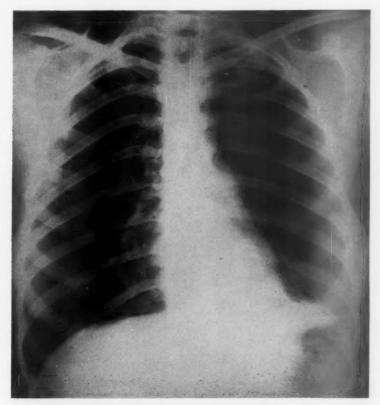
Chest x-ray on day of admission, showing small area of consolidation at left base.
